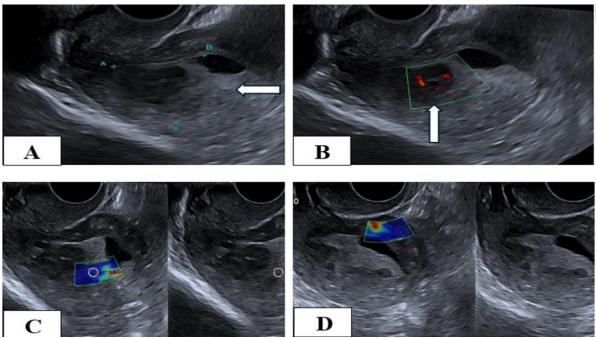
Submucosal Fibroid in a Thirty -five premenopausal Female patient presented by vaginal bleeding for 9 months. (A) Longitudinal B-mode TVS: shows small well defined heterogenous submucosal lesions largest measures 21x19 mm. (B) Colour doppler study shows central and peripheral vascularity. (C) SWE of the lesion reveals heterogenous color map with the E mean of the lesion =64.1 Kpa. (D) SWE of normal myometrium reveals the E mean of normal myometrium=49.6 Kpa. E/M ratio= 1.3
